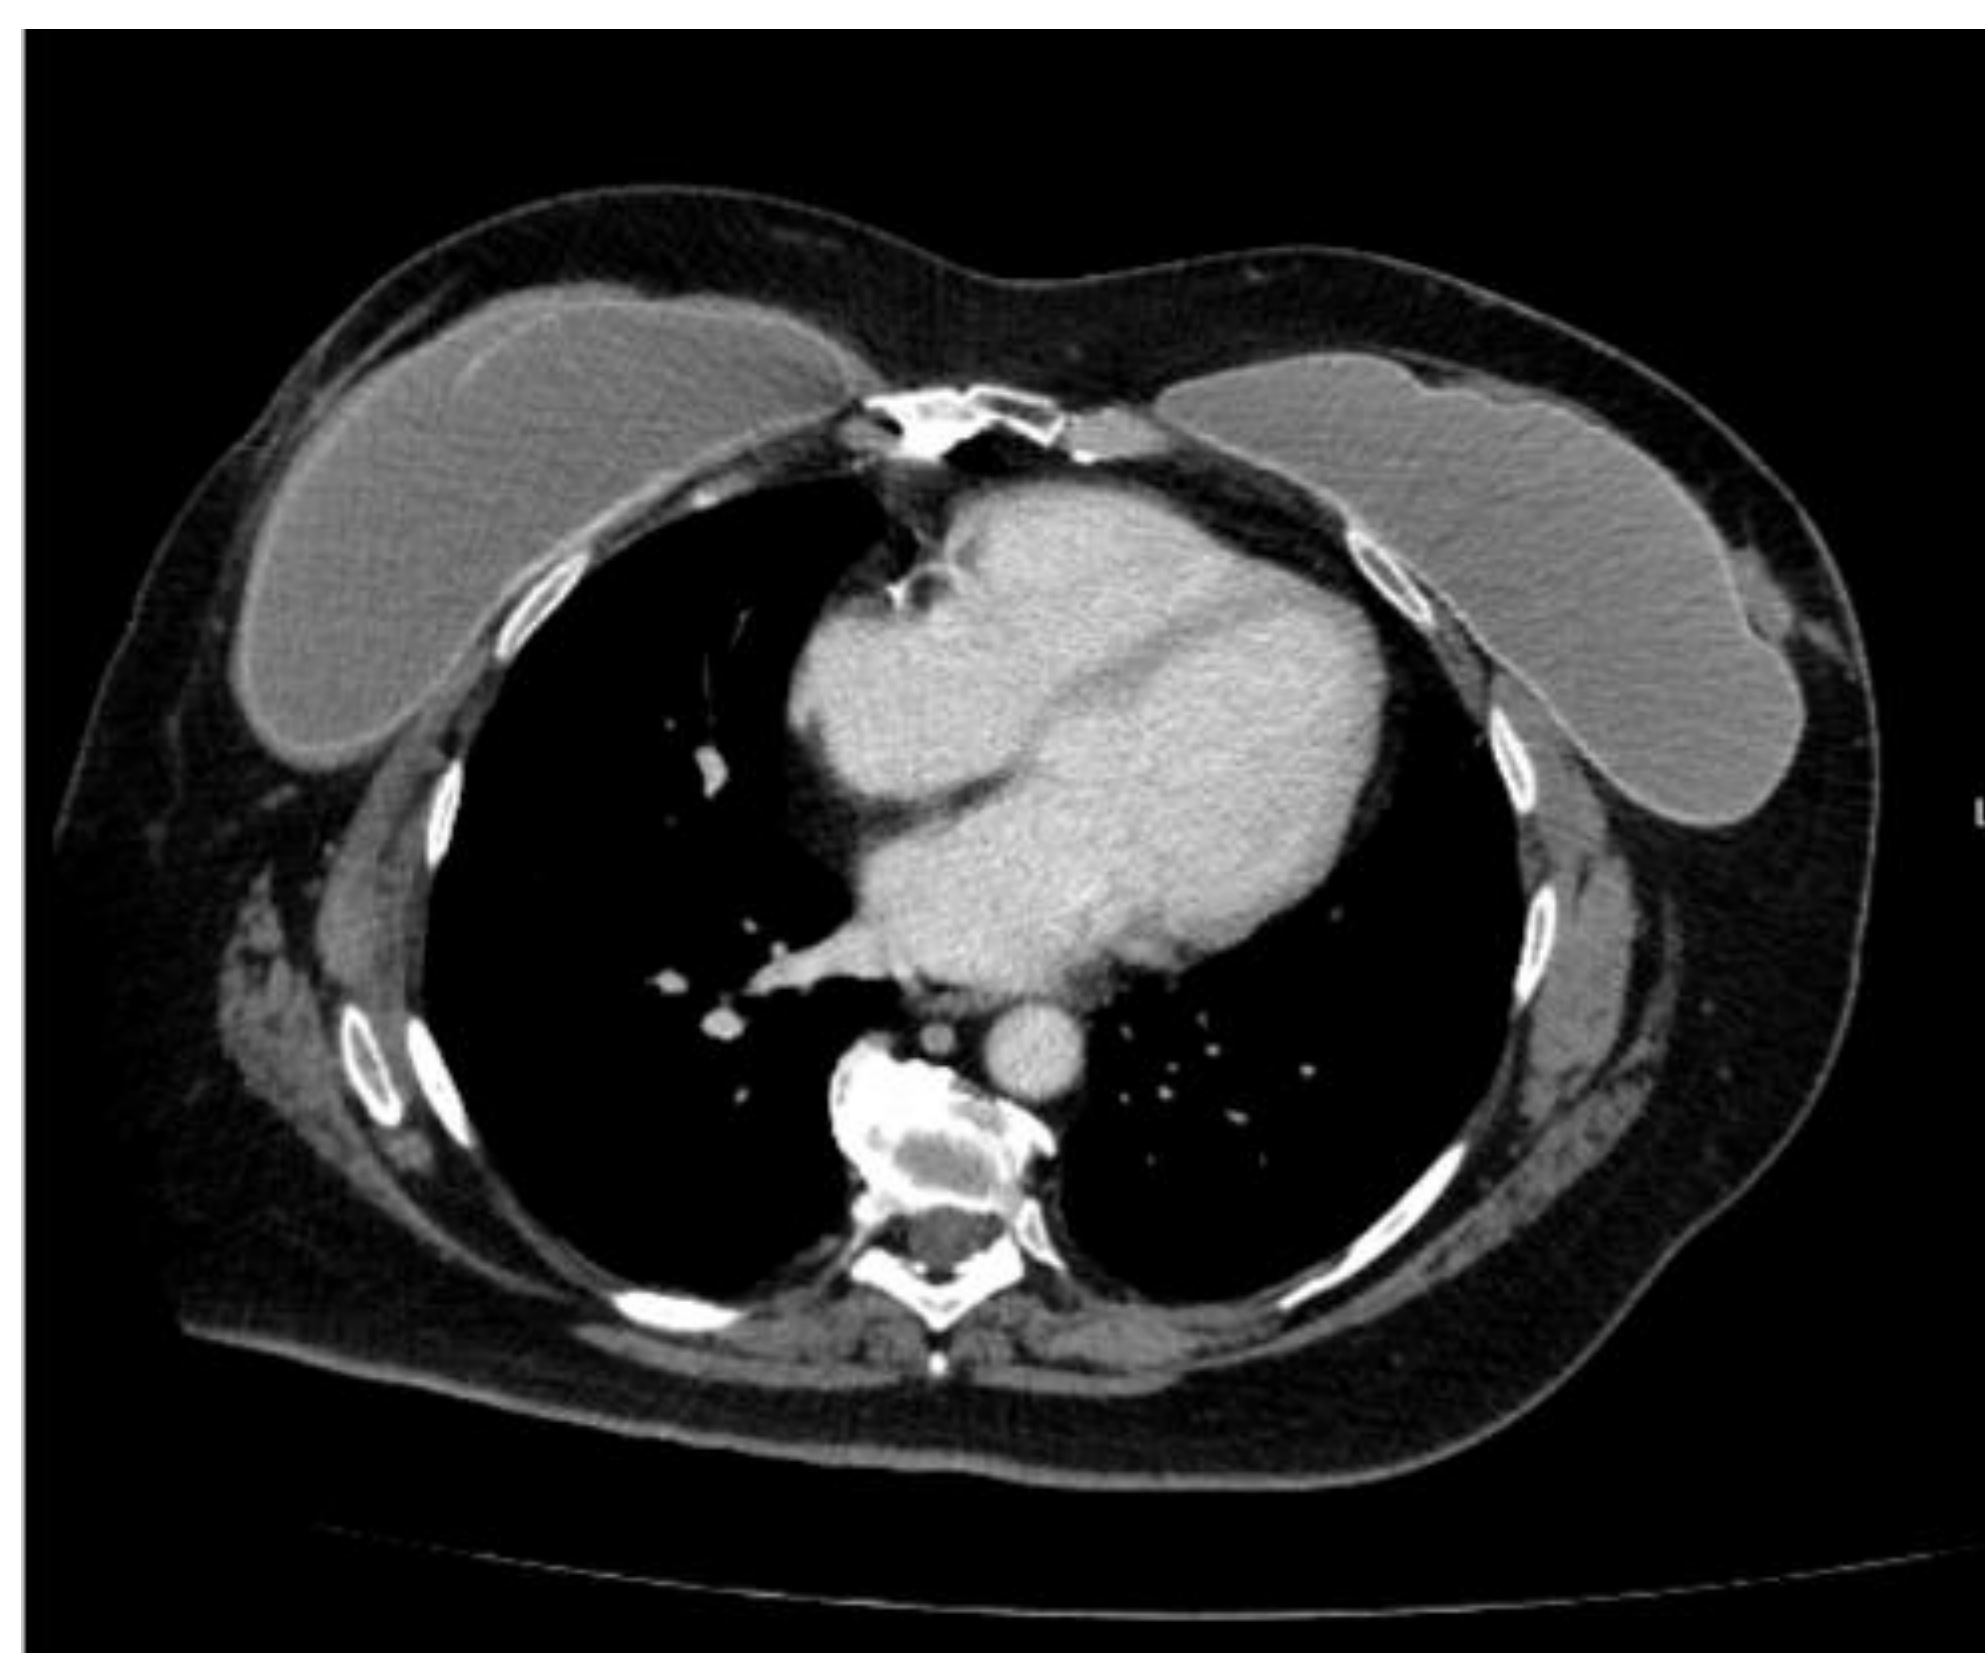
CT abdomen and pelvis demonstrating 2.4 x 1.0 x 1.4cm irregular-shaped hyperechoic mass located along the anterior margin of the left breast implant
